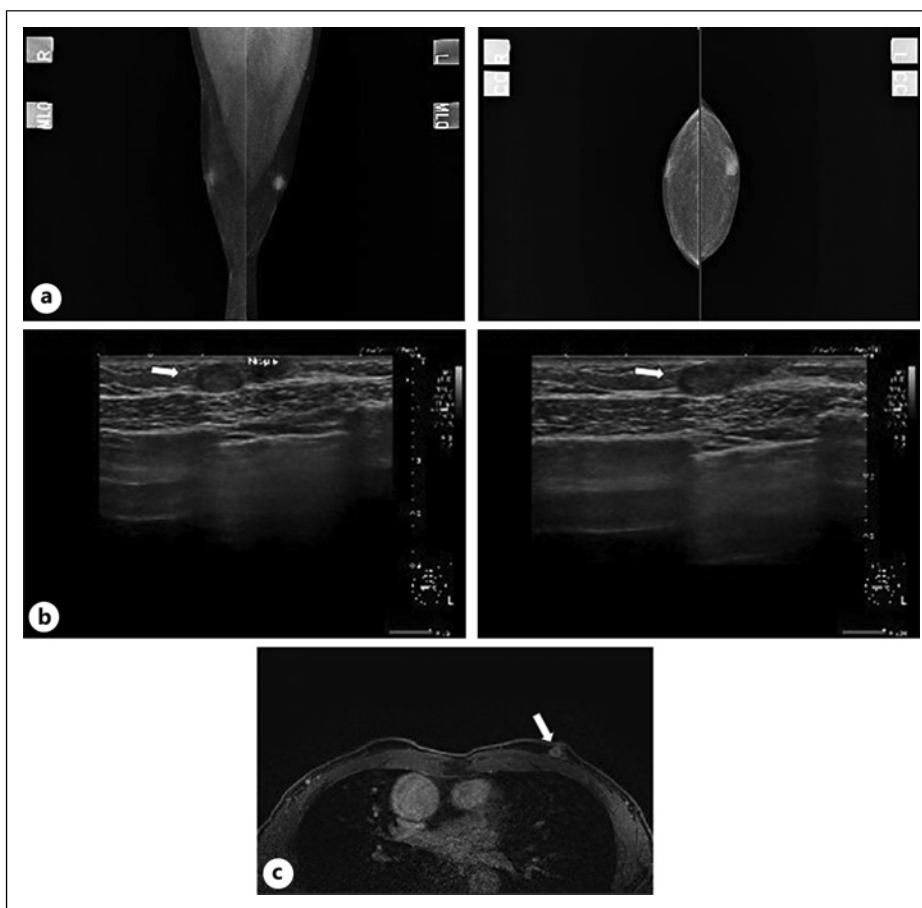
Mammography, ultrasonography, and magnetic resonance imaging (MRI) demonstrating the left breast tumor. a Mammography revealed a well-defined and high-concentration mass. b Ultrasonography scans exhibited an intracystic 10 mm mass under the left nipple without enlarged axillary lymph nodes. c MRI demonstrated a 7 mm intense early enhancement in the left breast.
